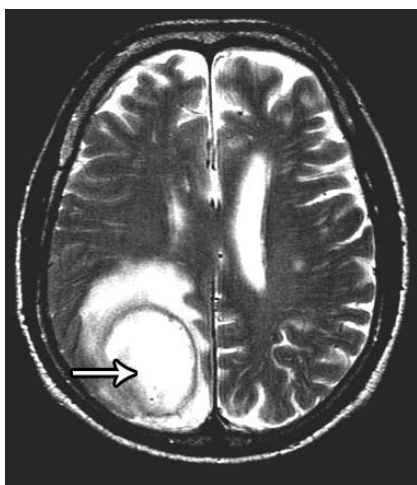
Axial T2 flair MRI showing the abscess in the right posterior parietal lobe.
